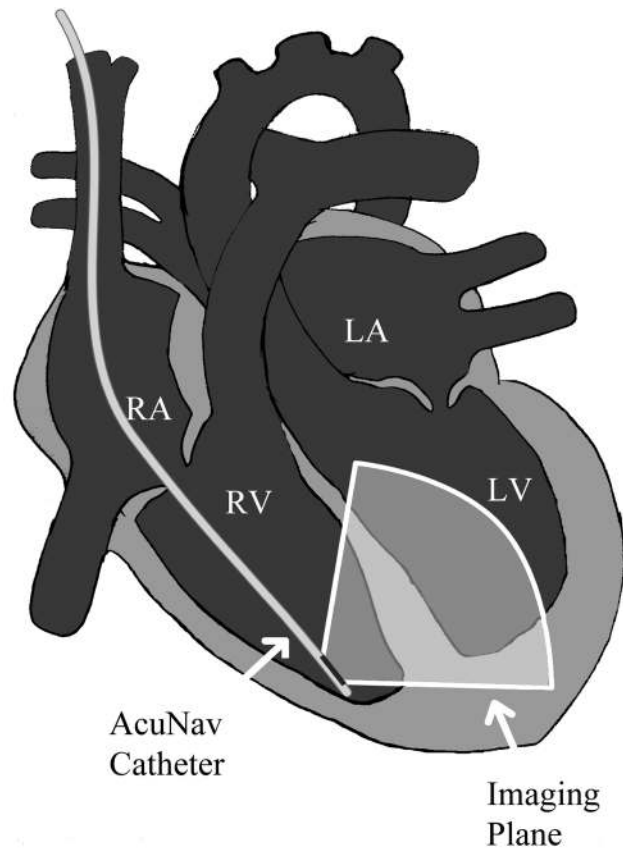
Ultrasound catheter tip placement. The imaging plane transects the interventricular septum.
